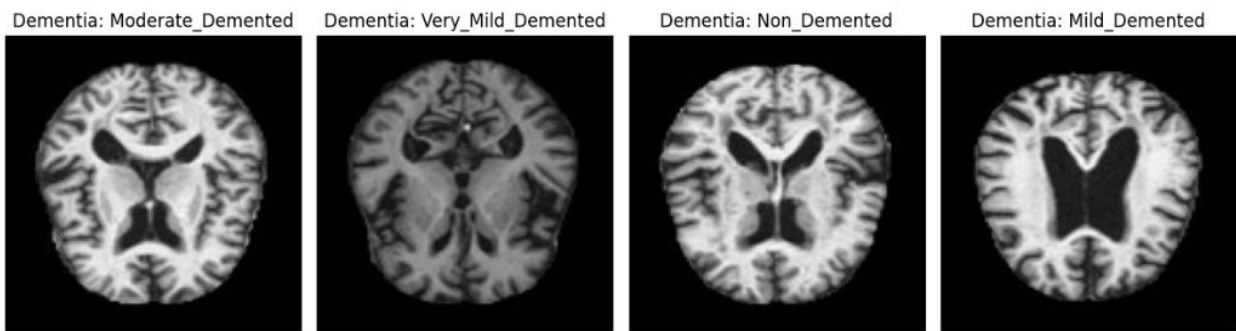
3 Sample labeled MRI images of dementia
